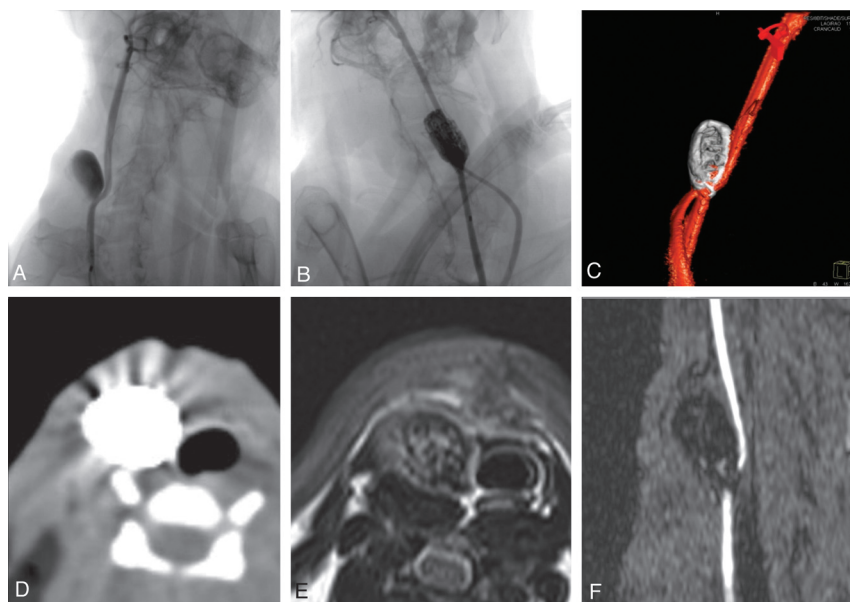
DSA demonstrates the anatomy of the venous patch carotid artery bifurcation model with the anastomosis of the left carotid artery proximal to the aneurysm (A and B). Posttreatment DSA (B) and 3D rotational angiography (C) show complete obliteration of the aneurysm (B). Note the persistent visibility of the right carotid artery despite superimposition by the coil mass. Note the minor effect of beam-hardening artifacts on the surrounding soft tissue on CT imaging (D). MR images demonstrate visibility of individual coil loops in the T2WI (E) and the lack of intra-aneurysmal flow in the TOF image (F).
